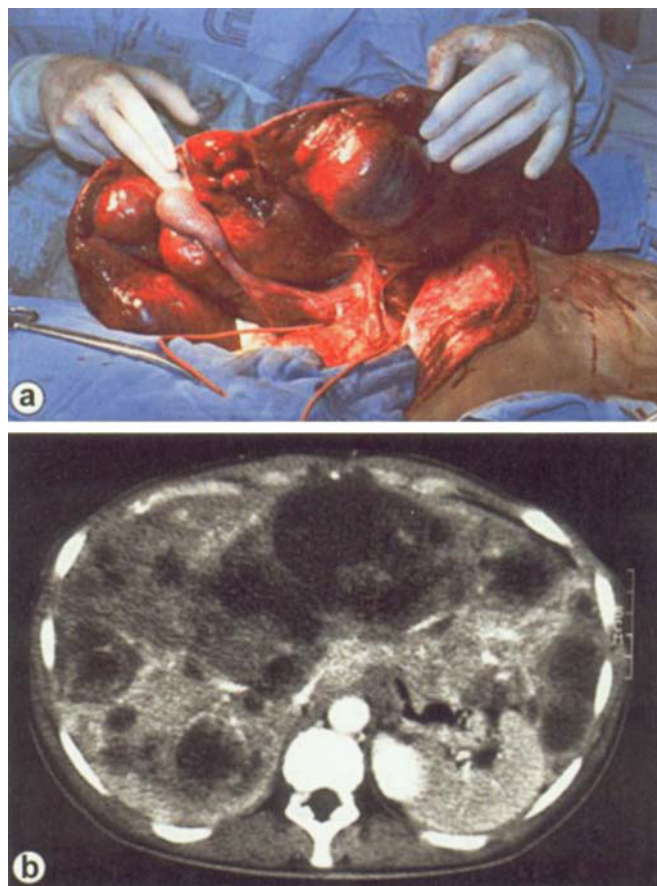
a Intraoperative view of 7.6 kg heavy haemangioendothelioma responsible for IVC syndrome and supine dyspnoea (OLT 787). b CT scan showing typical picture of advanced bi-lobar tumorous disease; the right liver contains several concentric zones of that result in different signal intensities
